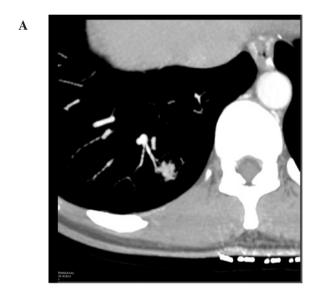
Contrast-enhanced CT image of the thorax with mediastinal windows showing the clearly lobulated mass as a hypervascular lesion. CT, computed tomography.
